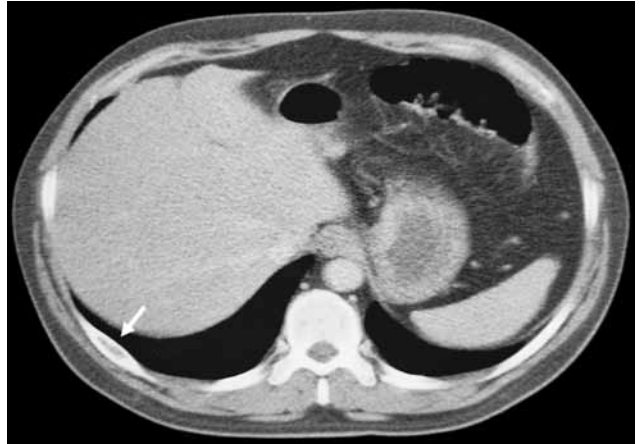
Thoracic computed tomography showing a small lytic lesion on the posterior arch of the right ninth rib.
